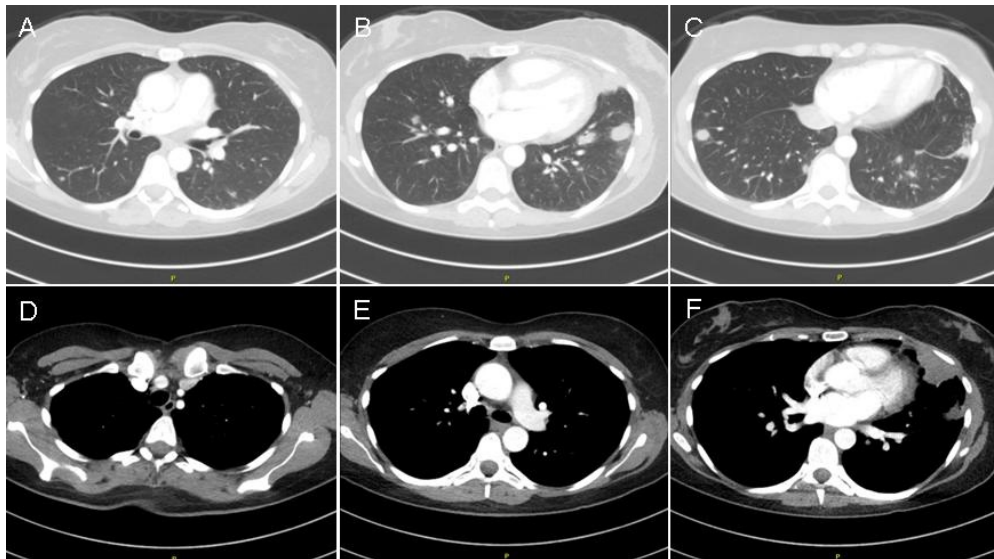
Representative images from the thoracic CT scan lung windows (A-C) and mediastinal windows (D-F).
